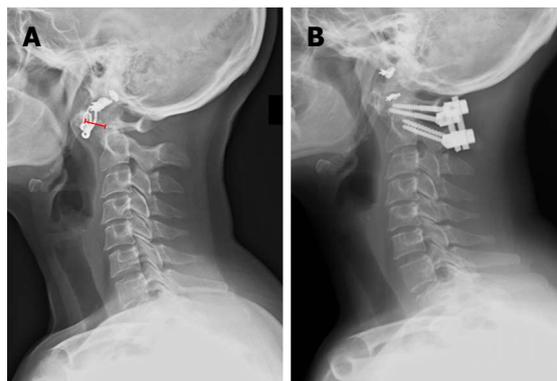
Lateral X-ray images of the spine before (A) and after (B) surgical intervention. The anterior atlantodental interval is shown (red line).
